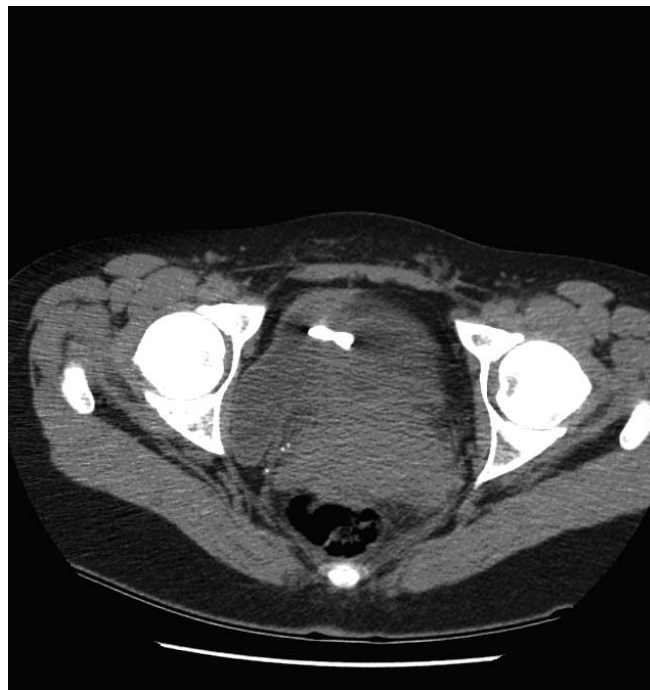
CT of an IUD extruding from the vagina into the bladder.
